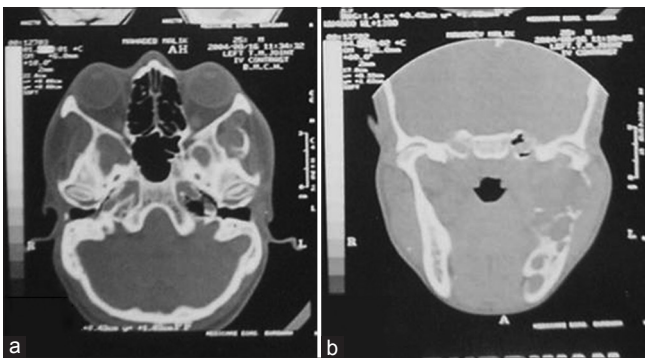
(a) Coronal slice of computed tomography (CT) scan showing expansion of medial and lateral border of left side of ramus with thick and curved bony septa and homogenous density; (b) Axial slice CT at level of mandible showing soft tissue mass in left side of mandible with complete destruction of buccal and lingual plate and remnant of bone within mass extending into adjacent soft tissue with loss of flat plane
